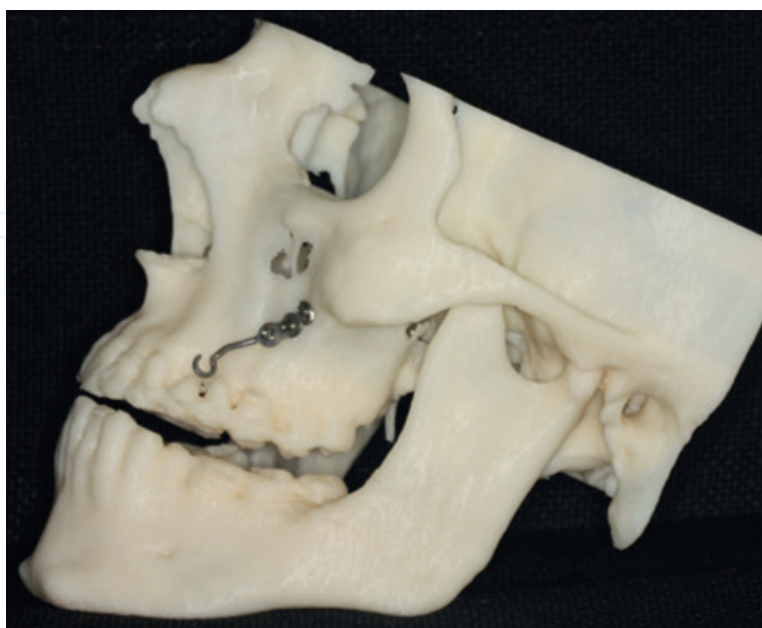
Planning and preparation of TAD (zygomatic skeletal anchorage) on a 3D model obtained from CBCT before surgery.
